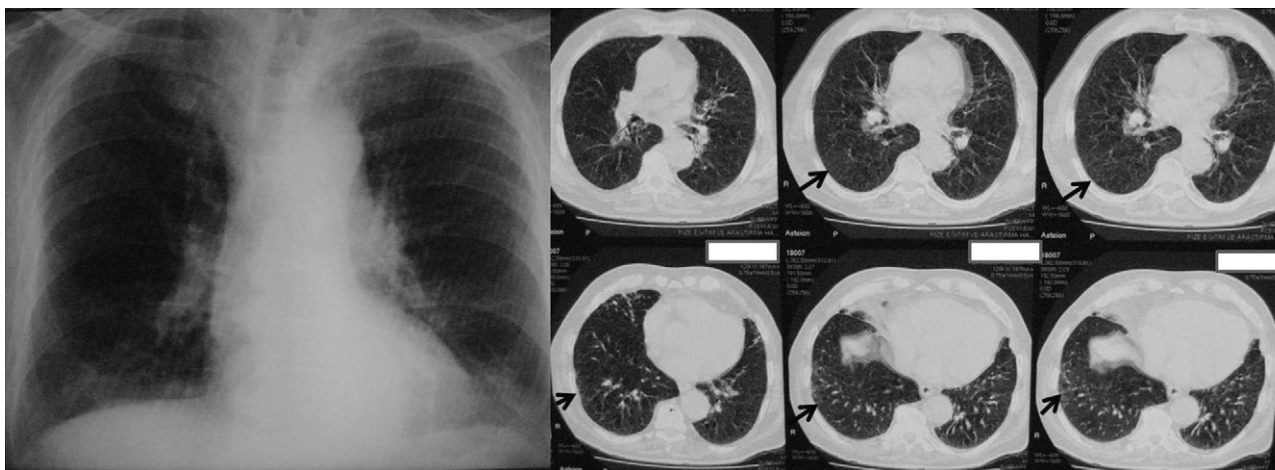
(Patient 5): The fifty five years old Turkish female patient was admitted to hospital with chronic cough and dyspnea. She had a eight years history of seropositive RA. She had also receiving immunosuppressive treatment. Chest radiograph and CT images showed nonspecific interstitial pneumonitis with reticulonodular and irregular linear opacities.
